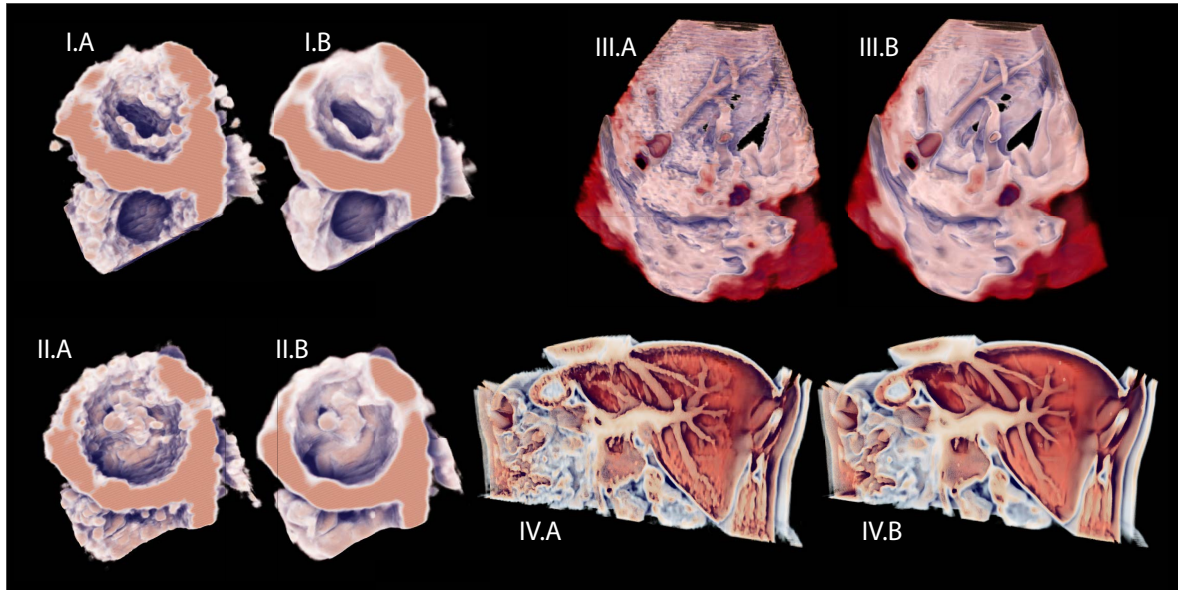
Comparison of non-filtered and filtered datasets from medical ultrasound and MRI: I. and II. 3D cardiac ultrasound, III. 3D ultrasound of liver, and IV. MRI of liver.
